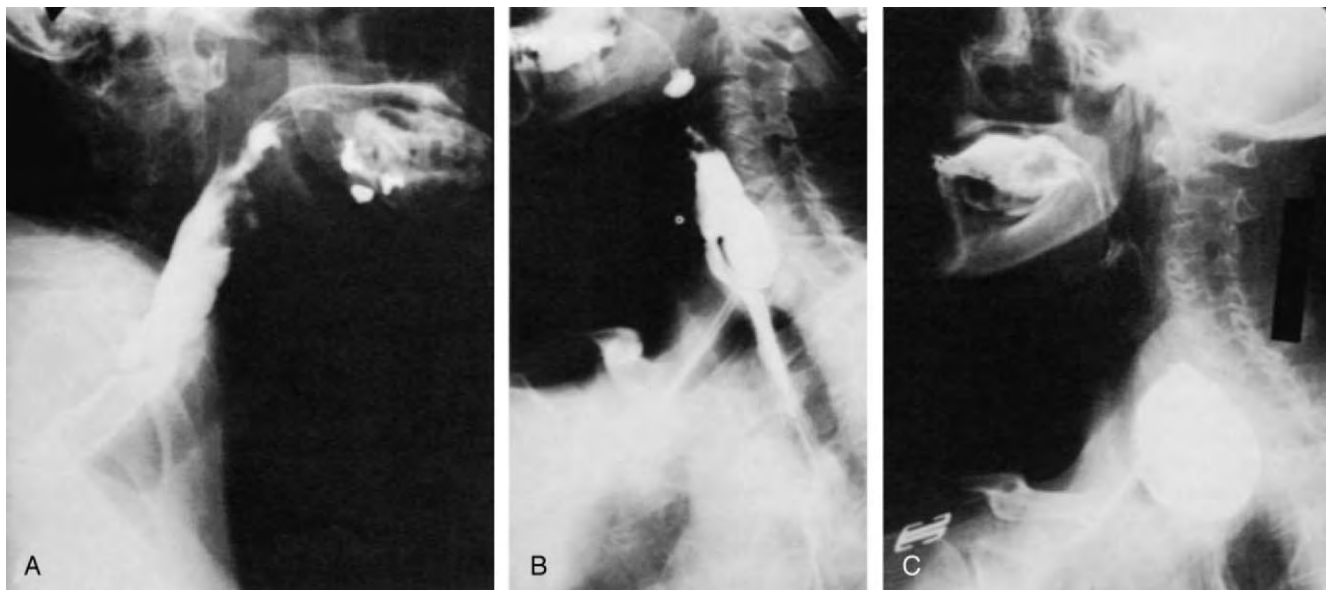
Radiographic appearance of various sizes of pharyngoesophageal diverticula. A, Small. B, Moderate. C, Large. (A and C From Payne WS: Diverticula of the esophagus. In Payne WS, Olsen AM [eds]: *The Esophagus*. Philadelphia, Lea & Febiger, 1974; B from Payne WS, Clagett OT: Pharyngeal and esophageal diverticula. *Curr Probl Surg* 23:1-31, 1965.)
